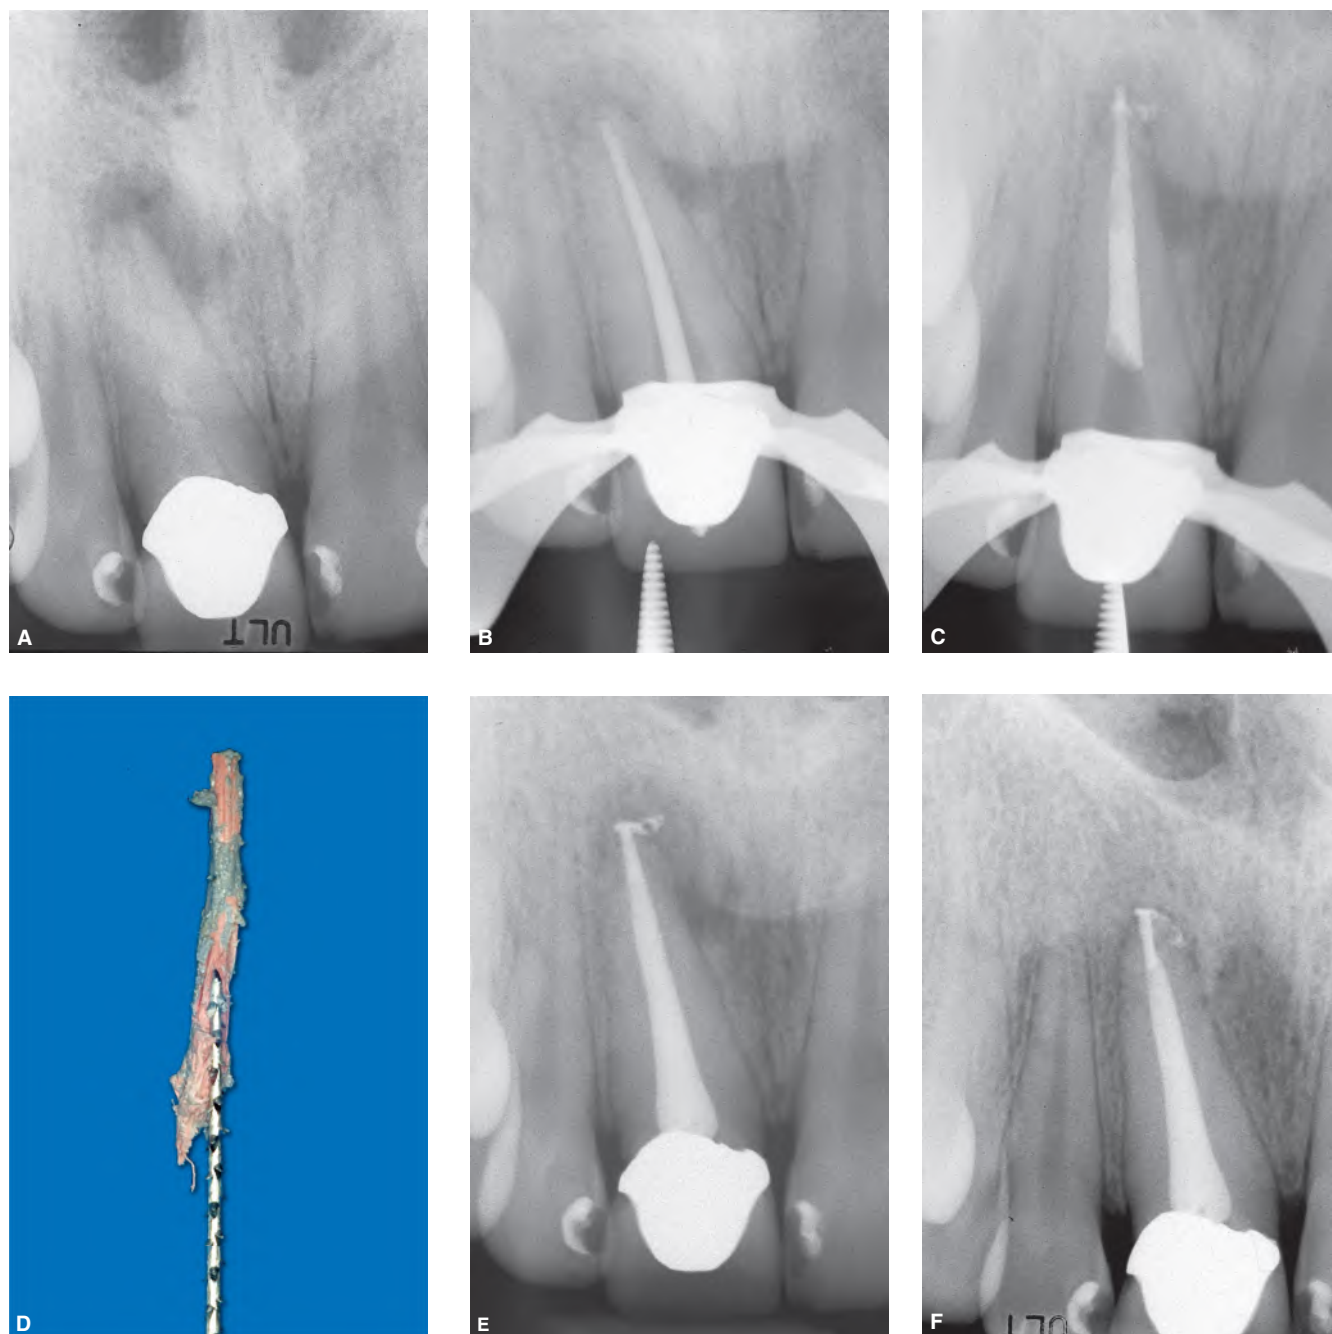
Owing to a previous improperly performed shaping, the master cone had a tug back only in the middle third of the canal, resulting in an inevitable extrusion of filling material beyond the apical foramen. The extruded gutta-percha was removed and the obturation completed with an Obtura syringe, using the sectional technique. A. Preoperative radiograph. B. Radiograph of the cone fit. Clinically, the cone presented a tug-back. C. Evidently, the tug-back was in the middle third of the canal. D. Using a large barbed broach, the gutta-percha cone was removed from the canal. E. Postoperative radiograph following obturation with the sectional technique of thermoplastic gutta-percha. F. Two-year recall radiograph showing successful results.
